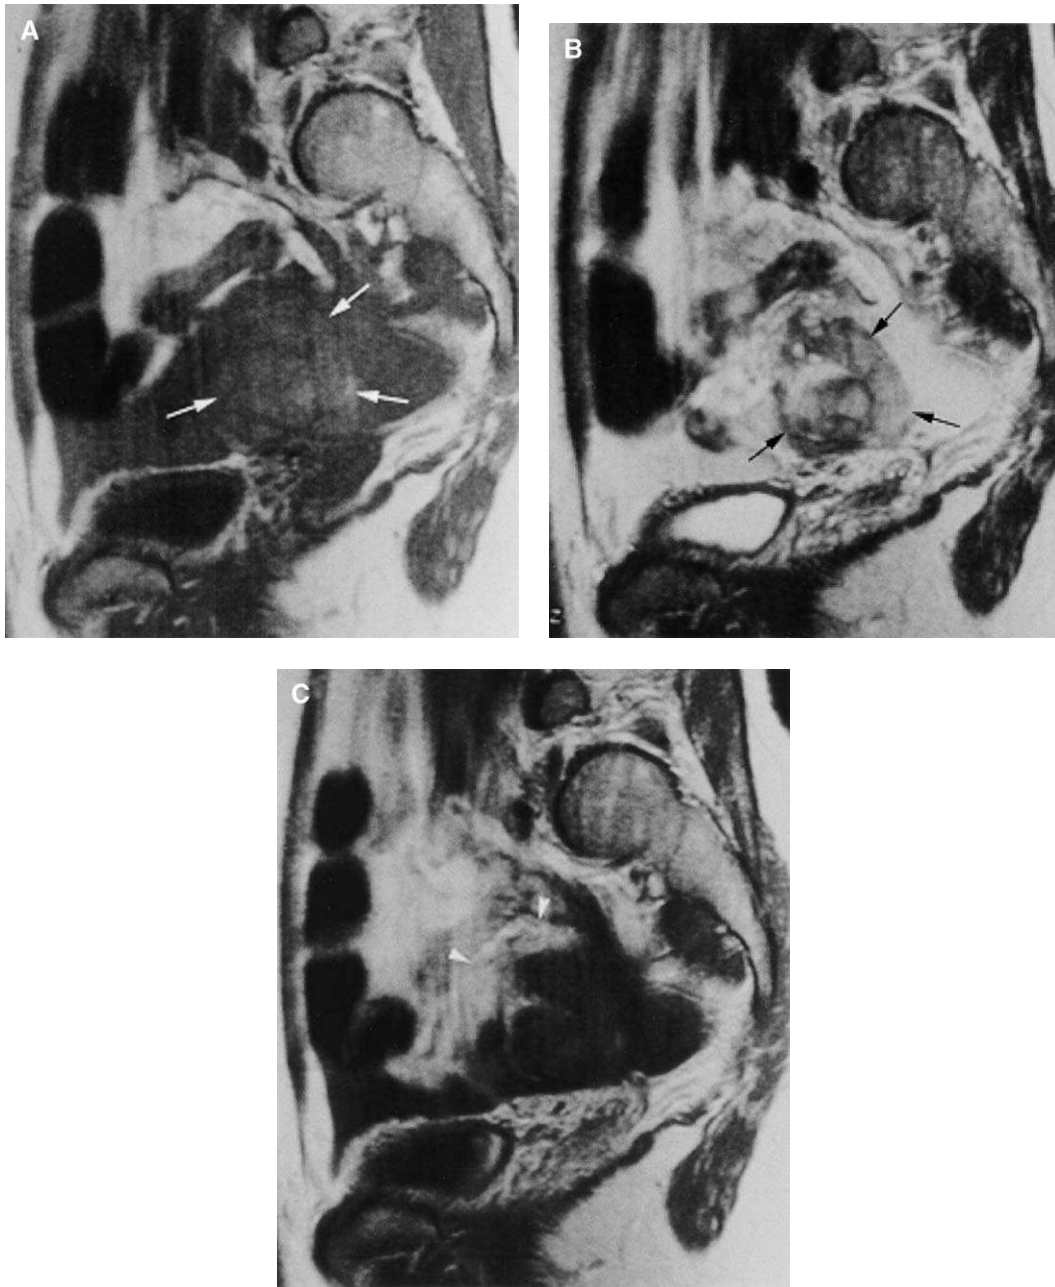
Ovarian bleeding from luteal hematoma in acute phase. (A) T1-weighted image shows free peritoneal fluid of intermediate signal and a mass (*arrows*) of mixed signal intensity that contains slightly higher signal intensity. (B) T2-weighted image shows mass (*arrows*) of mixed signal intensity that consists of high and distinct signal intensity within a free fluid that shows a lower signal than urine. (C) The wall of luteal hematoma is enhancing (*arrowheads*).
